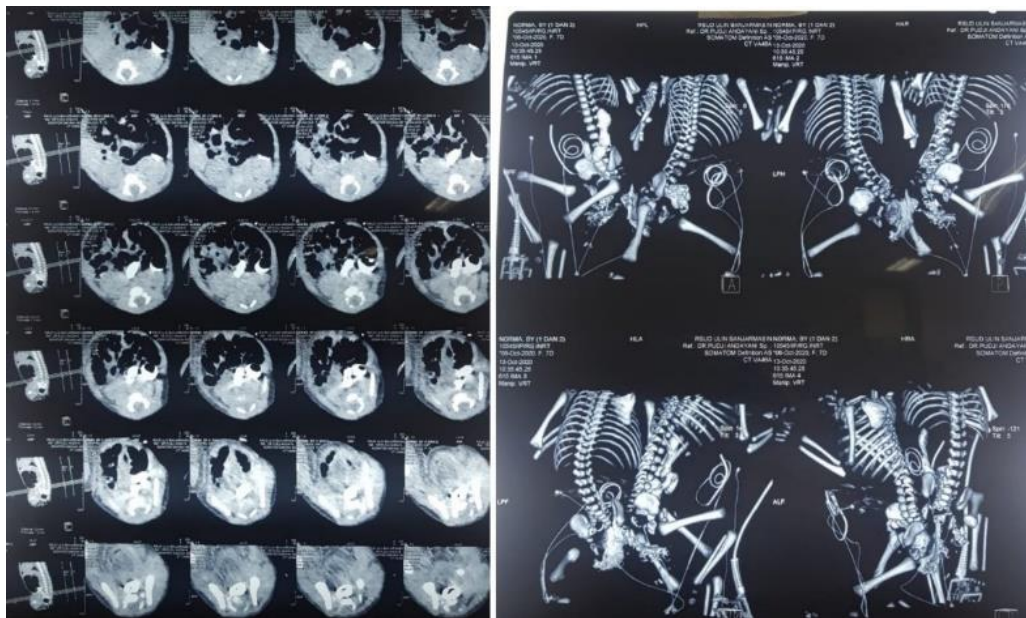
Computerized Tomography-scan (CT-scan) of the sacral region at 7 days of age. It showed conjoined twins with skin and subcutaneous fusion in the perianal area and no visible internal-vertebral-spinal fusion.
